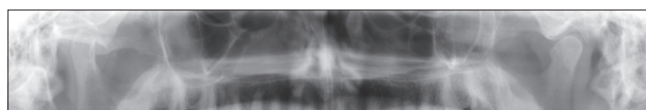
An orthopantomogram which shows asymmetry as crooked finger (type IV) - a bird beak (type III) for the right and left condyle
